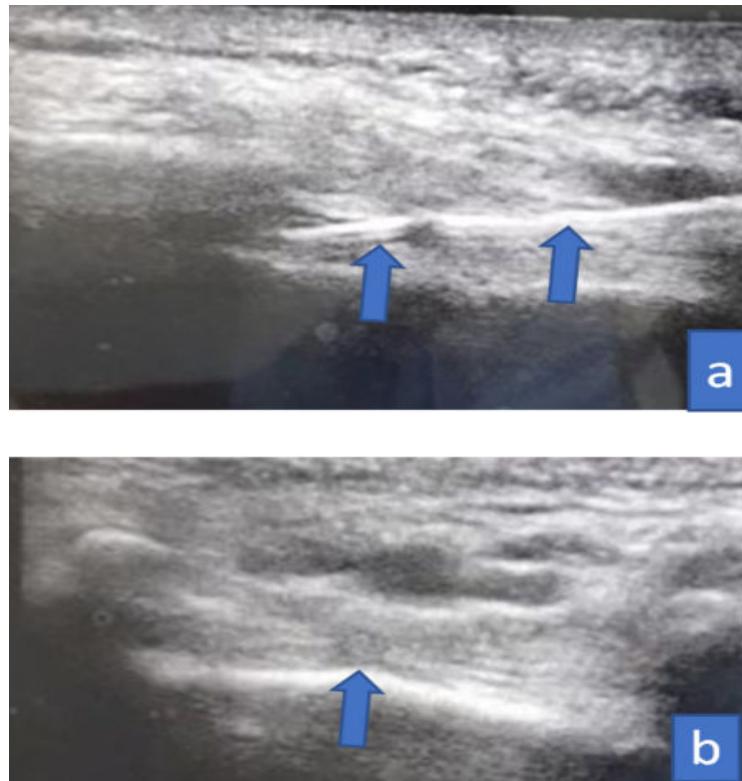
Ultrasound guide CPRF In-plane (a) and out-of-plane (b) blue arrow RF needle.
